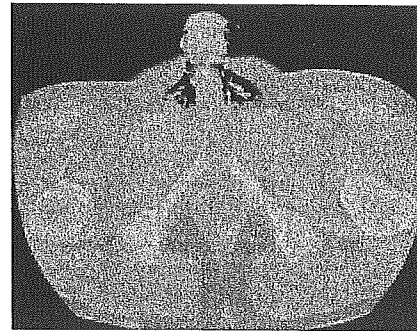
Abdominal computed tomography disclosed free air in the scrotum. Edited by Helen.
